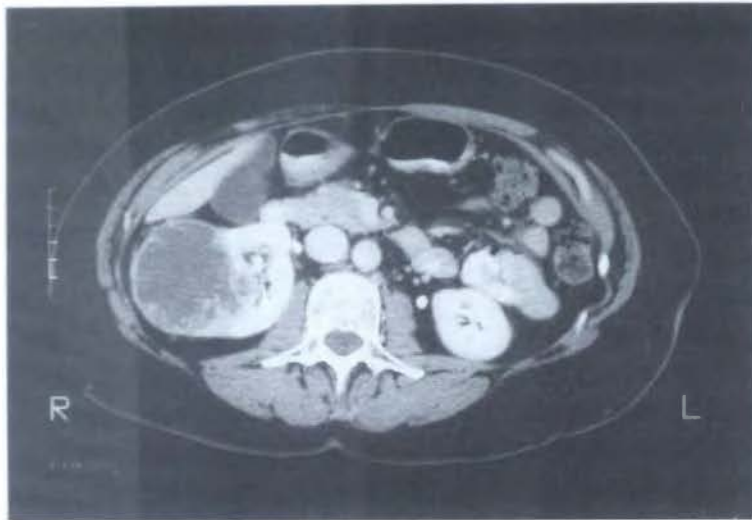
Computed tomogram of a 59-year-old female patient who presented with symptoms consistent with a kidney tumor. The patient's lower abdomen shows a large mass that has replaced much of the normal tissue in the right kidney (to the left in the image). The tumor forms a slightly darkened sphere more than 6 cm in diameter that is covered with a thin rind of normal kidney tissue. Pathological examination of the tumor after radical nephrectomy revealed that the tumor was a clear cell renal cancer entirely contained within the kidney capsule and showing no sign of invasion of other structures. Note the normal kidney lying to the right of the spinal column toward the bottom of the image, and the intestines viewed in transverse section to the upper right. (Photograph courtesy of Dr. William H. Bush and Dr. James A. Nelson, University of Washington School of Medicine.)
